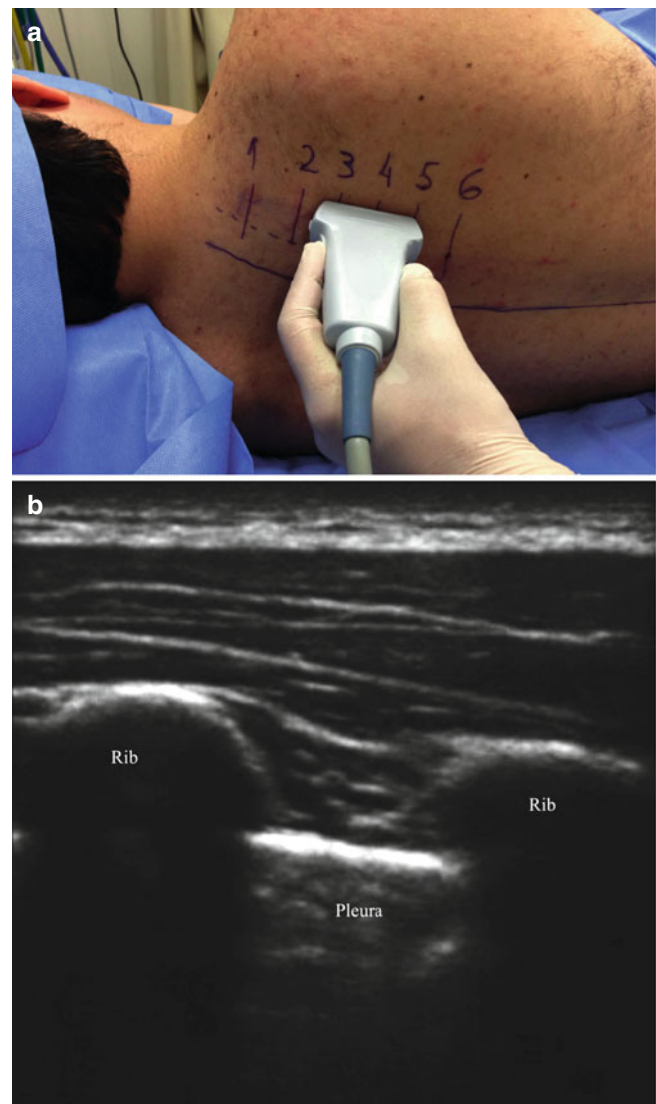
Ultrasound identification of the intercostal space, with the US probe placed vertically. (a) Location of probe; (b) US image showing rib, intercostal space, and pleura (Images courtesy of Thialgo Rouer Frederico, MD)
